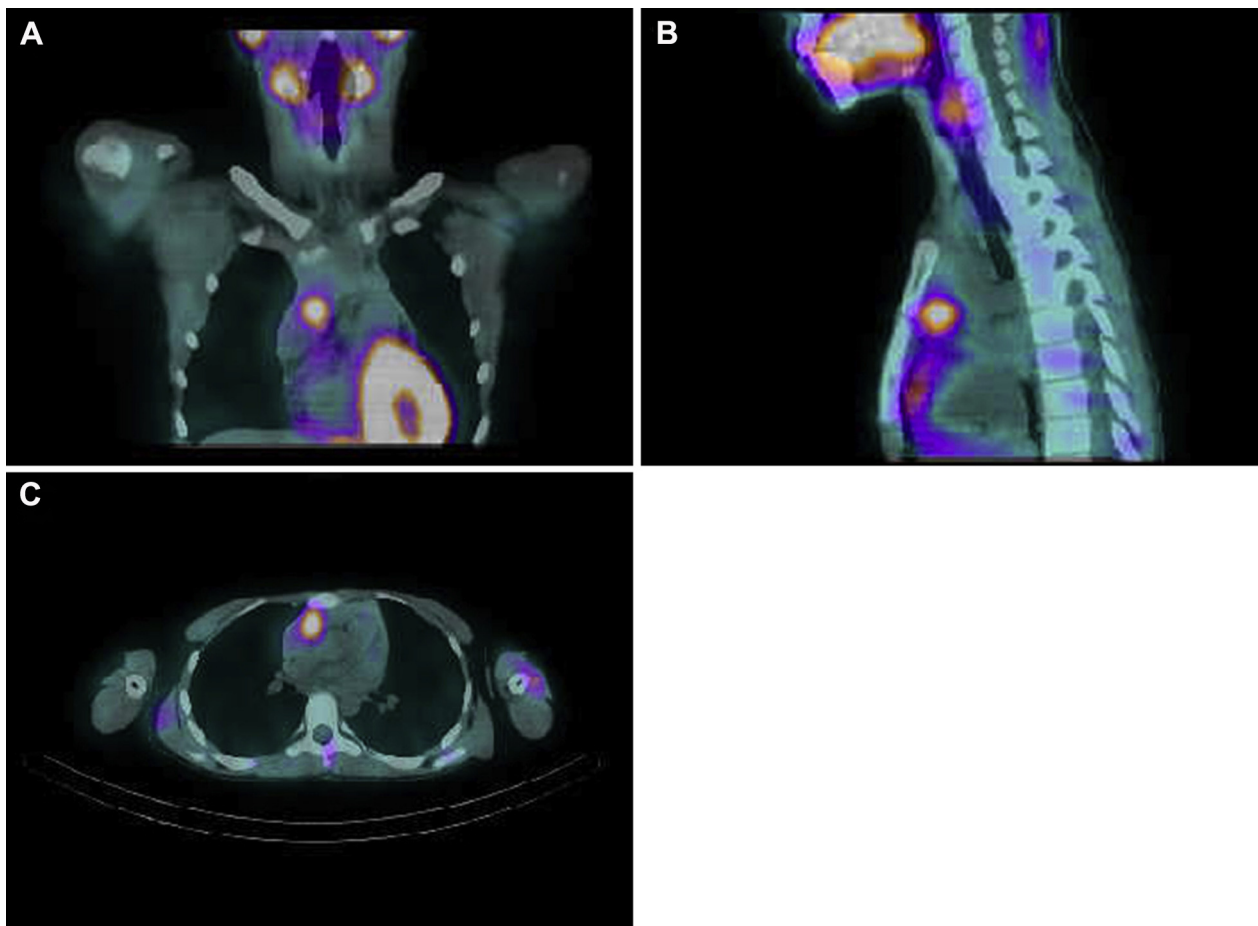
Coronal (A), sagittal (B), and axial (C) views of ^{99m}Tc sestamibi with SPECT/CT demonstrating the ectopic parathyroid adenoma.
